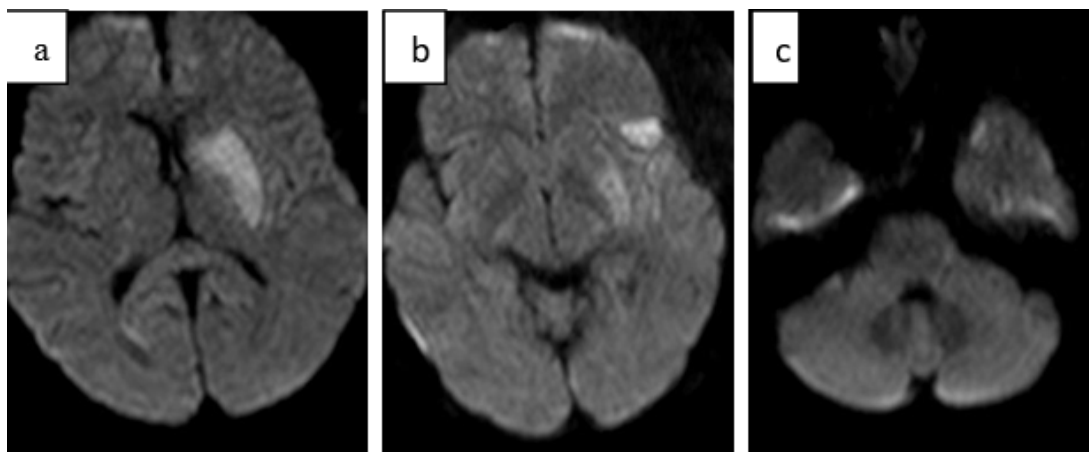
a: MRI brain DWI showing acute infarct in left ganglio capsular region; b: MRI brain DWI showing acute infarct in left frontal lobe; c: MRI brain DWI showing acute infarct in left temporal lobe.
